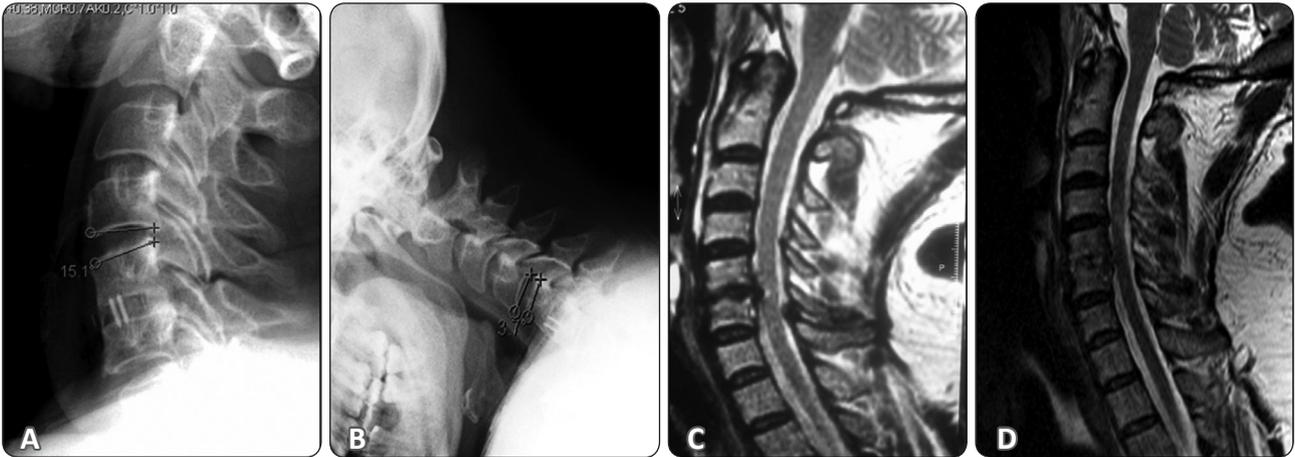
42 years old female The shell angle in cervical x-ray films obtained with patient in (A)extension, and (B)flexion, demonstrated high ROM (18.8) at disc level superior to that subjected to ACDF. Preoperative MRI (C) shows disc disease at C5-C6 and slight asymptomatic disc degeneration at the level above. Postoperative MRI (D) obtained 2 years after surgery demonstrates good C5-C6 decompression and increasing of C4-C5 disc disease
